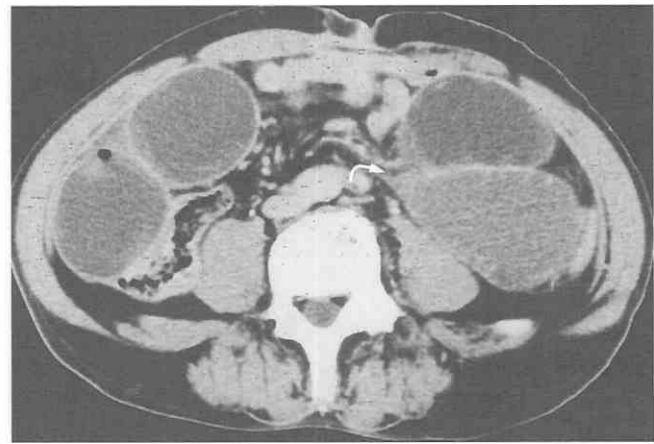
Simple small-bowel obstruction caused by adhesion and bands. CT scan shows diffuse dilatation of the small intestine with a smooth beak (arrow) at the site of obstruction. (From Ha HK, Rha SE, Kim JH, et al: CT diagnosis of strangulation in patients with small bowel obstruction: Current status and future direction. *Emerg Radiol* 2:47-55, 2000.)
